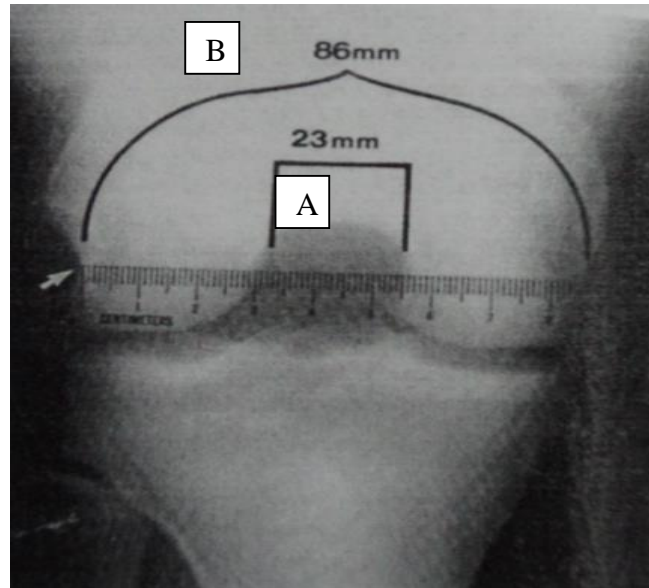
NWI measurement in a tunnel view radiograph: A / B, A- Intercondylar notch width (ICW), B- Bicondylar width (BW), NWI- Notch width index. Picture adapted from Souryal *et al.* (1988)
